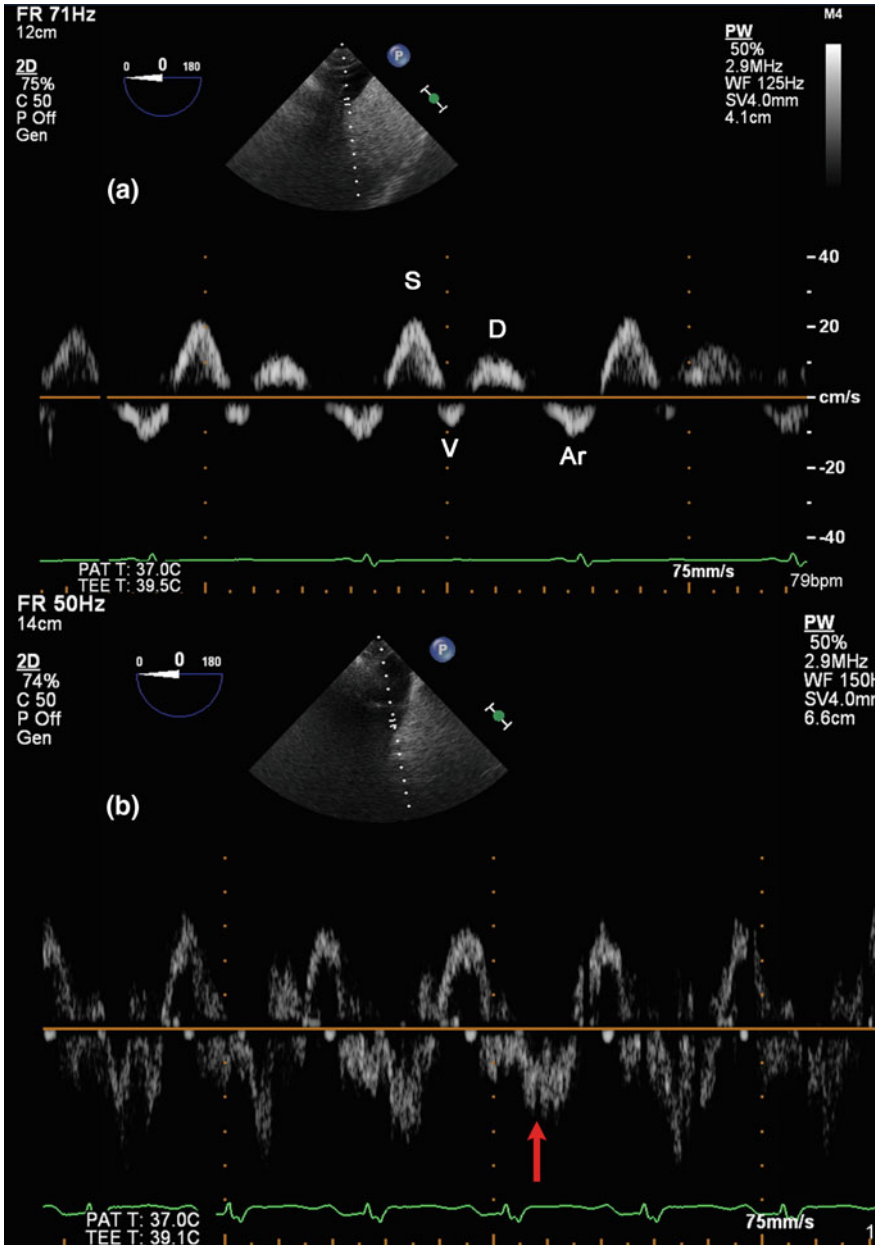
Pulsed wave Doppler of hepatic vein flow. The *top panel* (a) demonstrates normal hepatic vein flow with positive systolic (S) and diastolic (D) waves, and brief negative atrial (Ar) wave and variably present V wave. The *bottom panel* (b) demonstrates systolic flow reversal confirming severe tricuspid regurgitation
